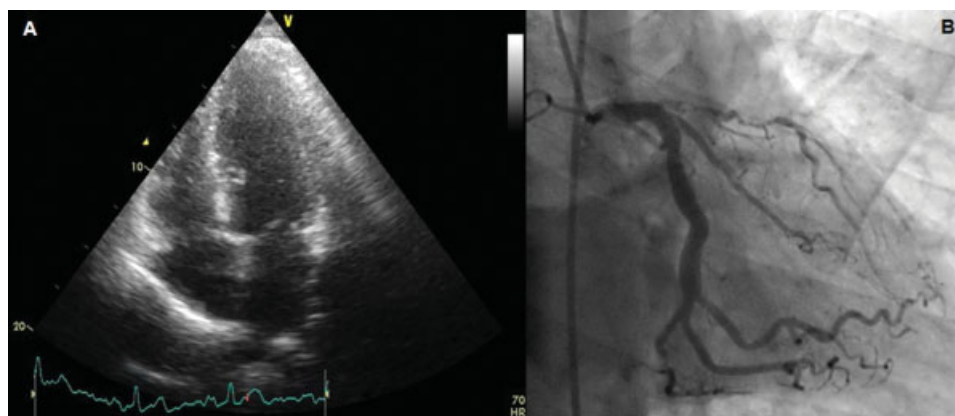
(A) Transthoracic echocardiography showed normal cardiac chambers. (B) Right caudal view of left anterior descending arteries showed critical stenosis at the proximal segment.
